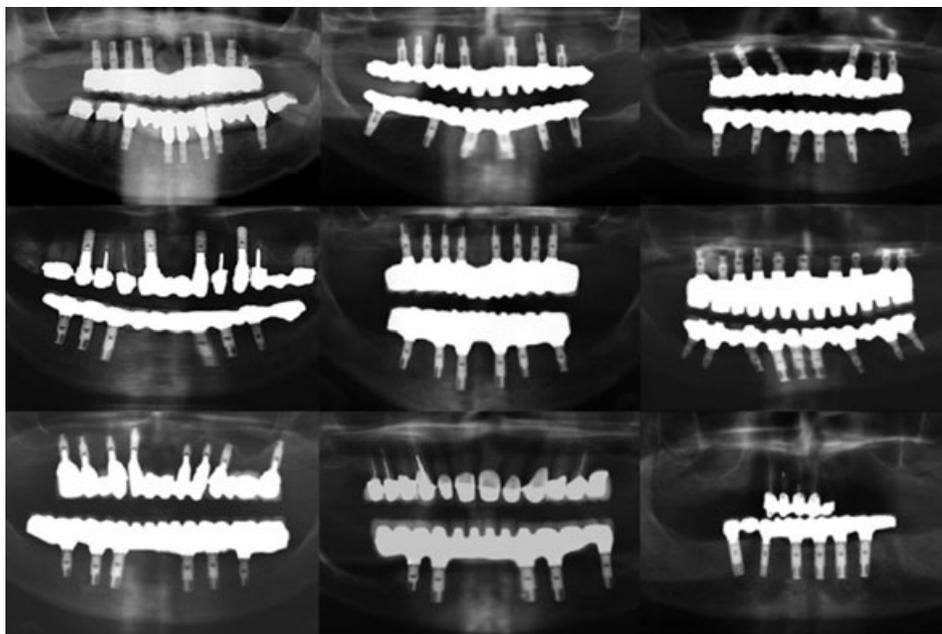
Panoramic radiographs of 11 out of 16 zirconia IFCDPs.
